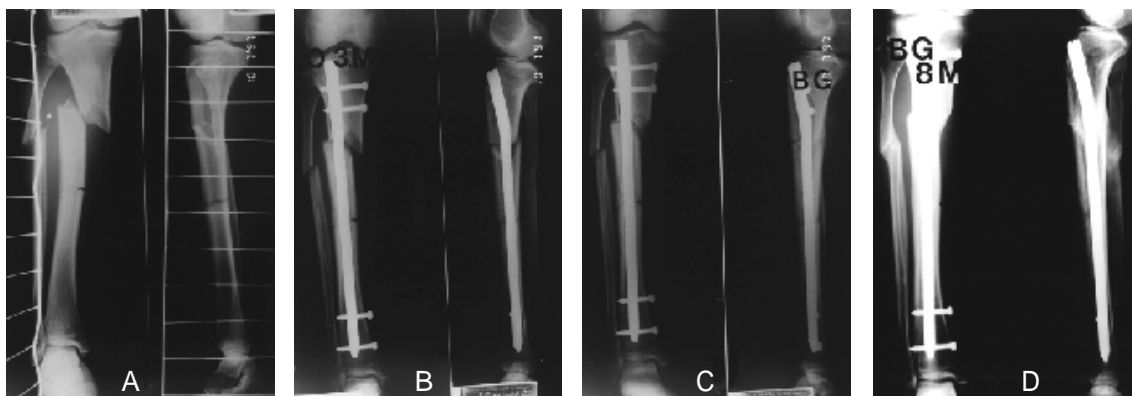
Initial x-ray shows segmental tibial fracture with severe displacement of proximal fragment.
